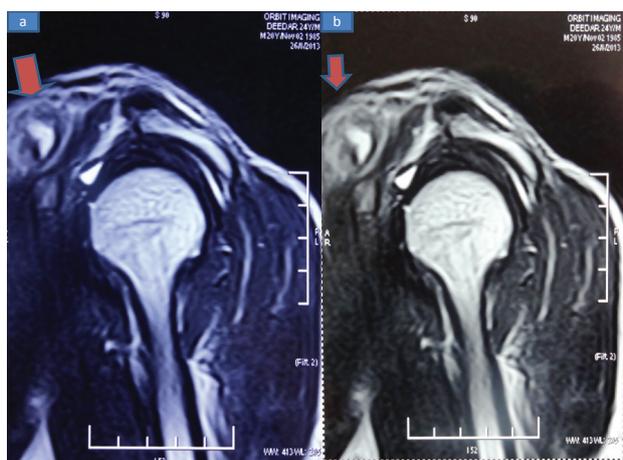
a) MRI study shows T1W hypointense and T2W hyperintense cystic lesion(arrow) involving clavicular part of deltoid muscle b) USG left shoulder shows evidence of well defined hypoechoic cystic lesion(arrow) with eccentric echogenic nodule suggestive of scolex with marked surrounding inflammatory reaction
